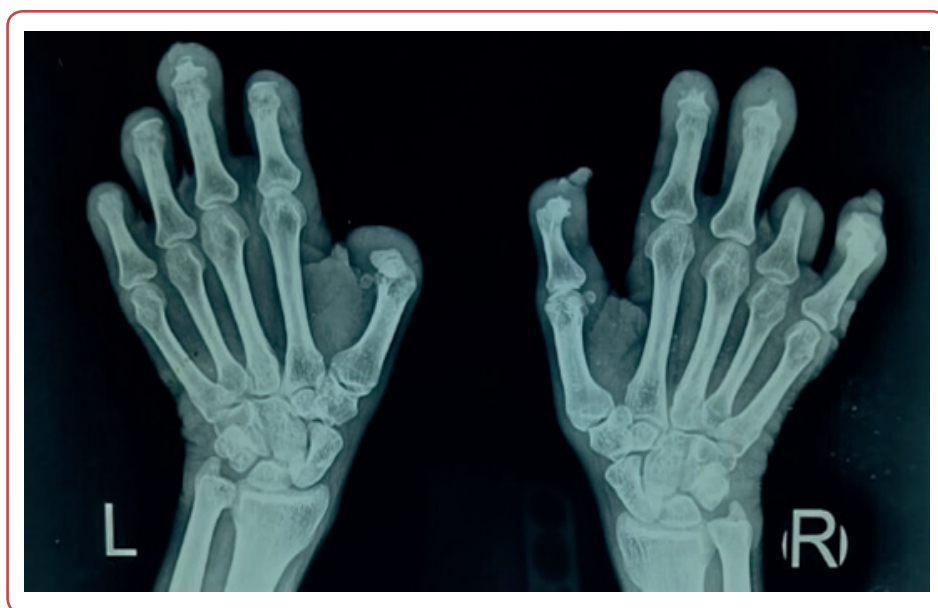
X-ray of hands and wrist joint (AP) of a patient with lepromatous leprosy (LL) showing: complete resorption of all terminal phalanges of both hands, partial resorption of all middle phalanges of both hands except the 4th digit of the right hand which shows complete resorption along with partial resorption of proximal phalanx. Soft tissue thickening also seen in digits of both hands with periarticular osteopenia.
